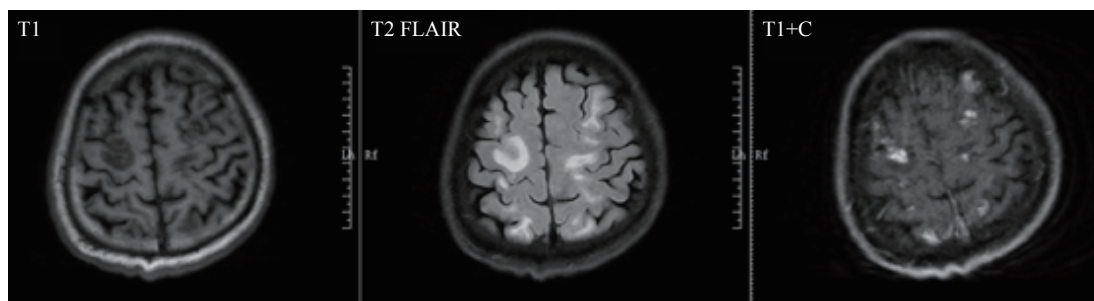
MRI findings reveal multiple symmetrical abnormal signals in the bilateral frontal, parietal, temporal, and occipital lobes, as well as the periventricular regions of the bilateral lateral ventricles. Abbreviation: MRI=magnetic resonance imaging.
